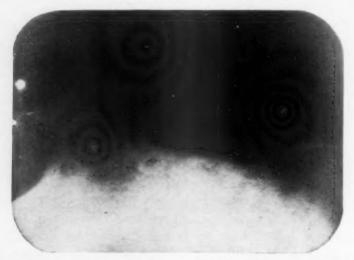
X-ray of alveolar ridge showing osteolytic area which was thought to be due to destruction by carcinoma, but which proved to be the unhealed extraction wound.
